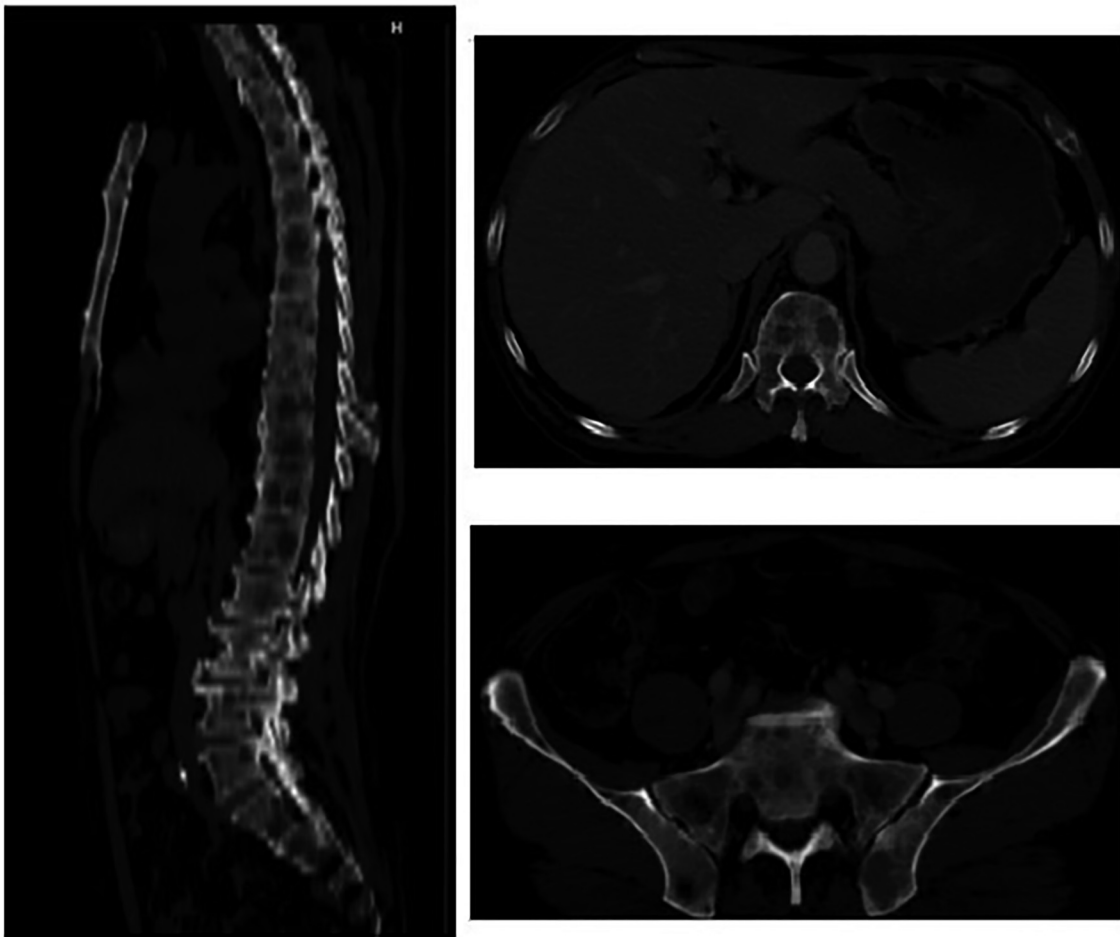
CT scans showed multiple lytic bone metastases in vertebral and pelvis bone in April 2021.
